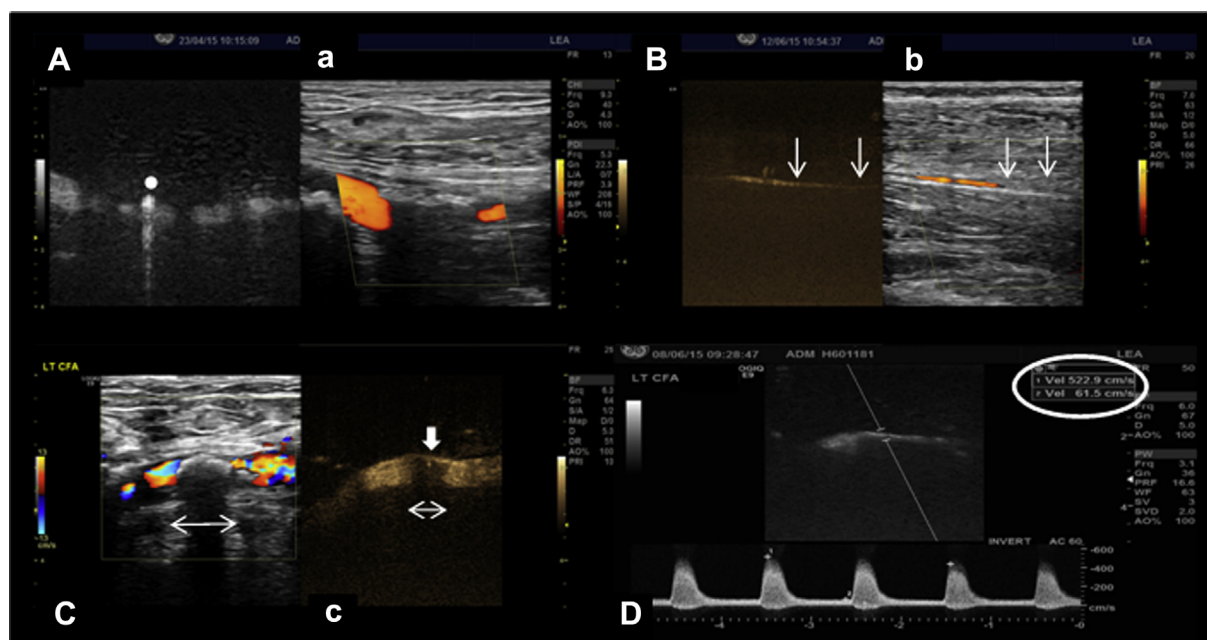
(A) B-Flow image of the distal common femoral artery and SFA origin. There is marked calcification of the SFA walls, indicated by the strong reflections (*circle*). The calcification is more prominent on the power angio flow image (a). There is no obvious evidence of flow within the calcified region; therefore, the patency of the vessel cannot be determined using Power angio alone, yet on the B-flow image there is evidence of a partially patent lumen within the same region of calcification (a), resulting in valid information for interpretation of the scan. (B) B-Flow image and power angio image of an anterior tibial artery taken from a diabetic patient. On the power angio image (b), the distal segment of the proximal ATA appears occluded (*arrows*); however, on the B-flow image, the artery is patent but of small caliber (*arrows*). (C) Color flow image of a calcified CFA. There is a calcified plaque with acoustic shadowing (*double-headed arrow*). The scale was lowered to 13 cm/s to optimize flow; however, aliasing is observed with no significantly raised velocities proximal and distal to the plaque. Flow waveforms were monophasic with low velocities in the proximal SFA, suggesting a possible CFA occlusion. On the B-flow image (c) a significant reduction of the lumen was noted. Doppler velocities were measured (D), and a severe stenosis (>90%) rather than an occlusion was identified. SFA = superficial femoral artery; ATA = anterior tibial artery; CFA = common femoral artery.
